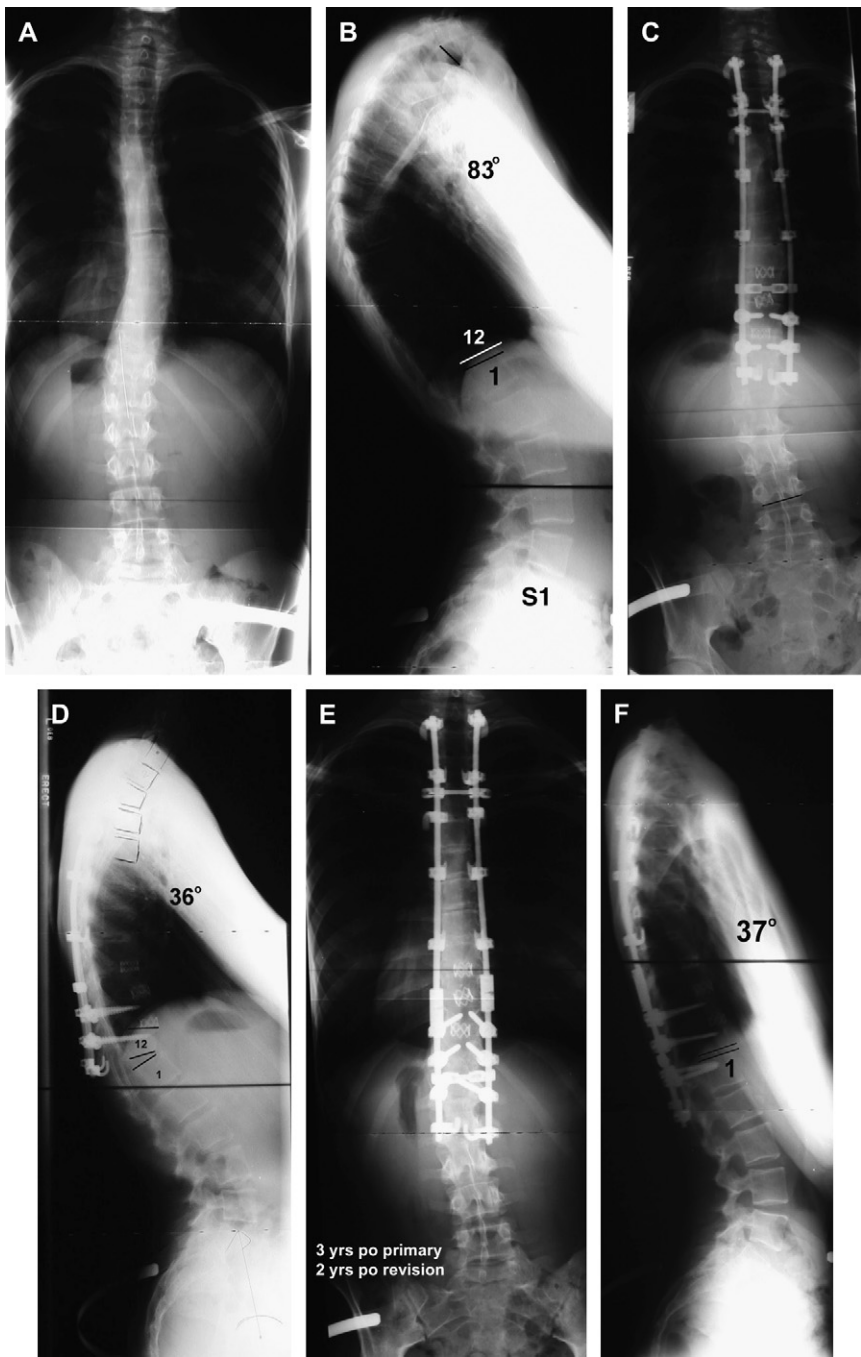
(A–F) Radiographs demonstrate distal junctional kyphosis related to not including the first lordotic level distally. The instrumentation was extended one level distally with resolution of the distal junctional kyphosis.
